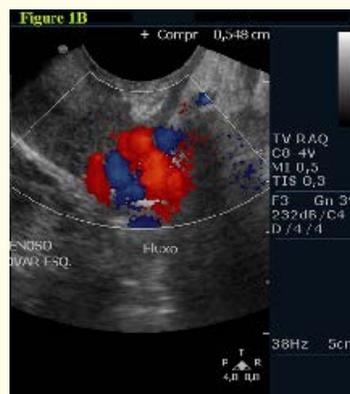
Ultrasound confirms varicose veins beside the ovaries through the scale of colors.
